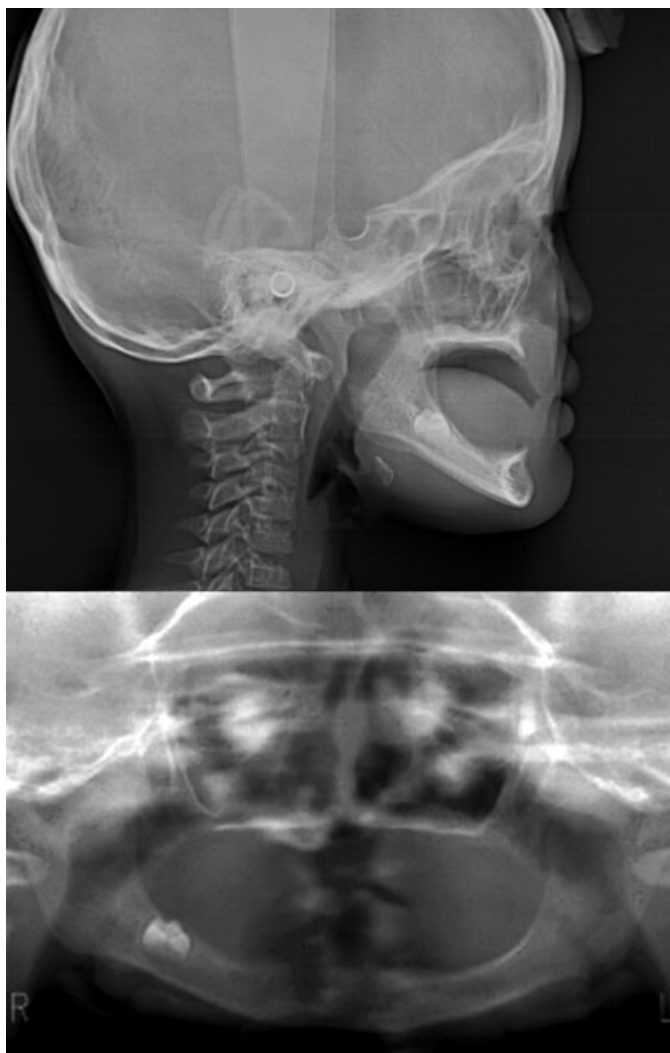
Lateral cephalogram (upper panel) and panoramic radiograph (lower panel) of the Mongolian individual with hypohidrotic ectodermal dysplasia. Note the extremely short alveolar height of both jaws and only one tooth in the right mandible.
